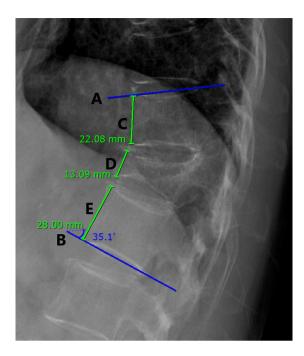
Five lines (A–E) of the thoracolumbar vertebrae in x-ray radiographs were determined. The Cobb angle was measured using the angle between the superior endplate of the vertebral body above (line A) and the inferior endplate of the vertebral body below (line B) the fractured vertebral body. The length of the line (C, D, E) was used to calculate the compression ratio.
